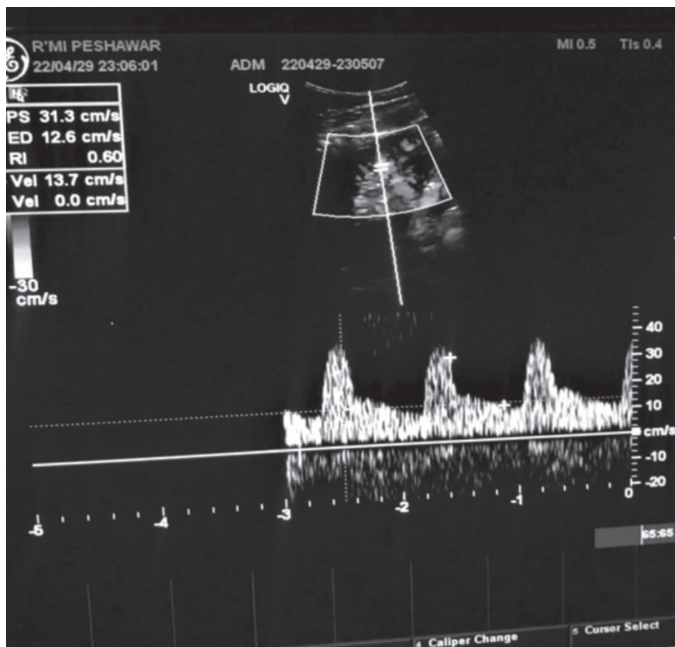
Day 7 Doppler US of perfused kidney with 3 arteries, shows normal RIs.
